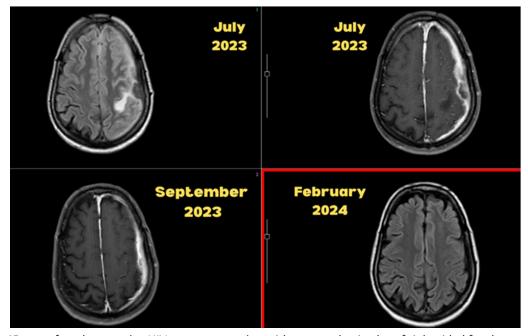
45 years female, negative HIV status presenting with repeated episodes of right sided focal onset motor seizure with head adversion to right with secondary generalization. MRI head shows Vasogenic edema involving the left parietal lobe with overlying thickened T2 hypodense enhancing pachymeninges (July 2023). Progressive reduction in the pachymeningeal enhancement after 2 months of ATT (September 2023) and complete resolution of the thickened meninges and vasogenic edema (February 2024).
